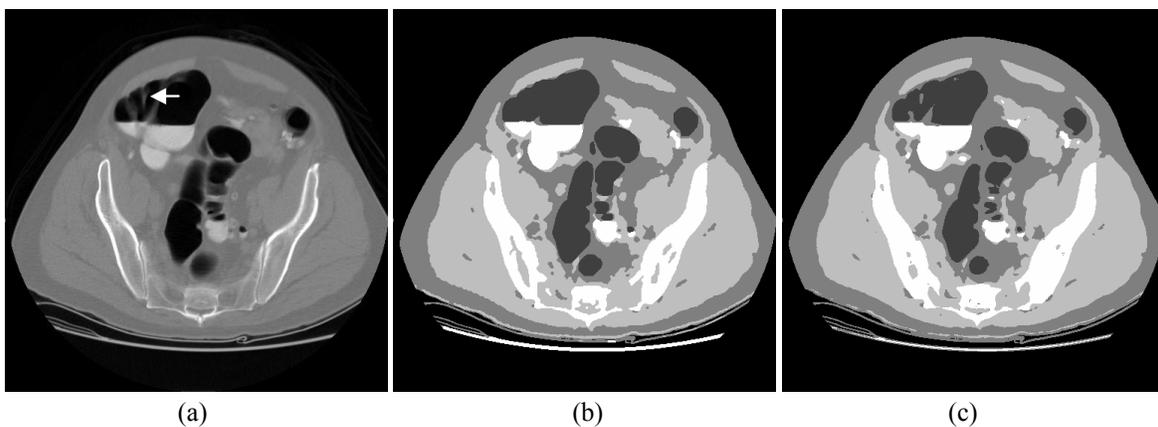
Clinical patient CT image study. (a) shows the original image; (b) is the hard segmentation by our previous MAP-MRF-based method [16]; and (c) is the converted hard segmentation from our current PV method of Figure 2 below.
